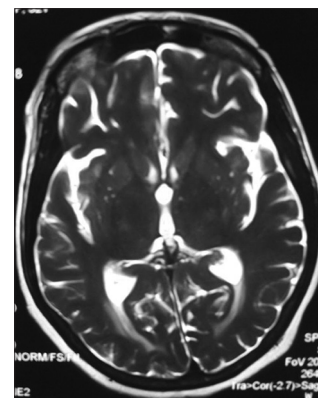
Repeat T2-weighted magnetic resonance imaging showing significant reduction in brain edema
